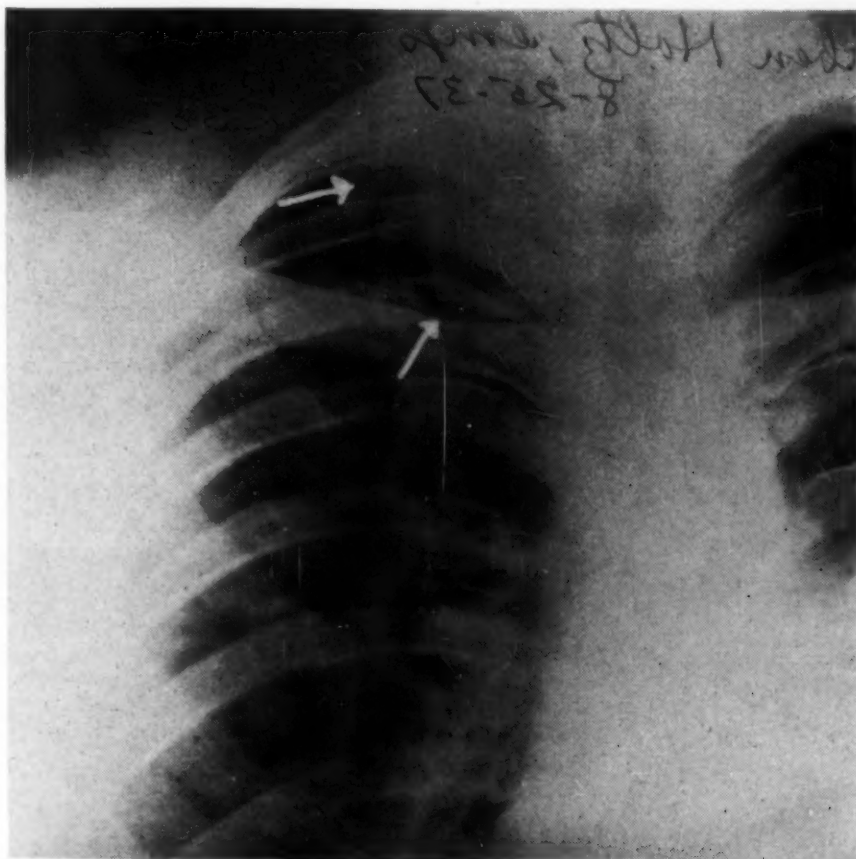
Case 4: Employee's original roentgenogram of 8-25-37. Small circumscribed mass in right apex.
